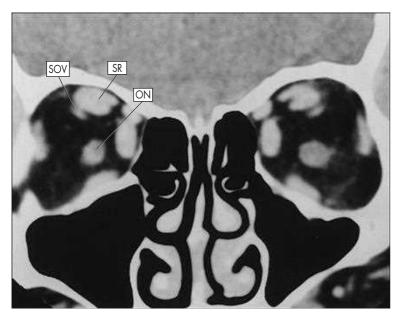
Coronal CT Scan Through the Midorbit. The optic nerve lies centrally, surrounded by the rectus muscles. Just below the lateral edge of the superior rectus is the superior ophthalmic vein. *ON*, Optic nerve; *SOV*, superior ophthalmic vein; *SR*, superior rectus muscle.
